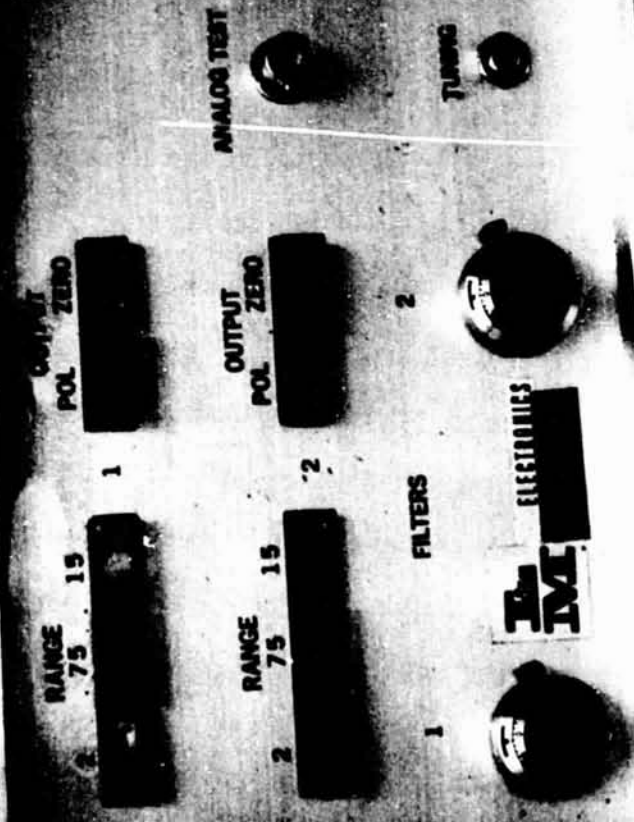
Ames two channel directional Doppler flowmeter for centrifuge use.
